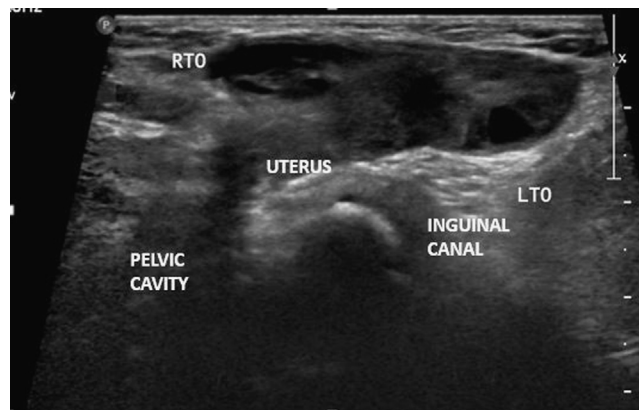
Ultrasonography of the left groin reveals herniation of ovaries into the inguinal canal.
